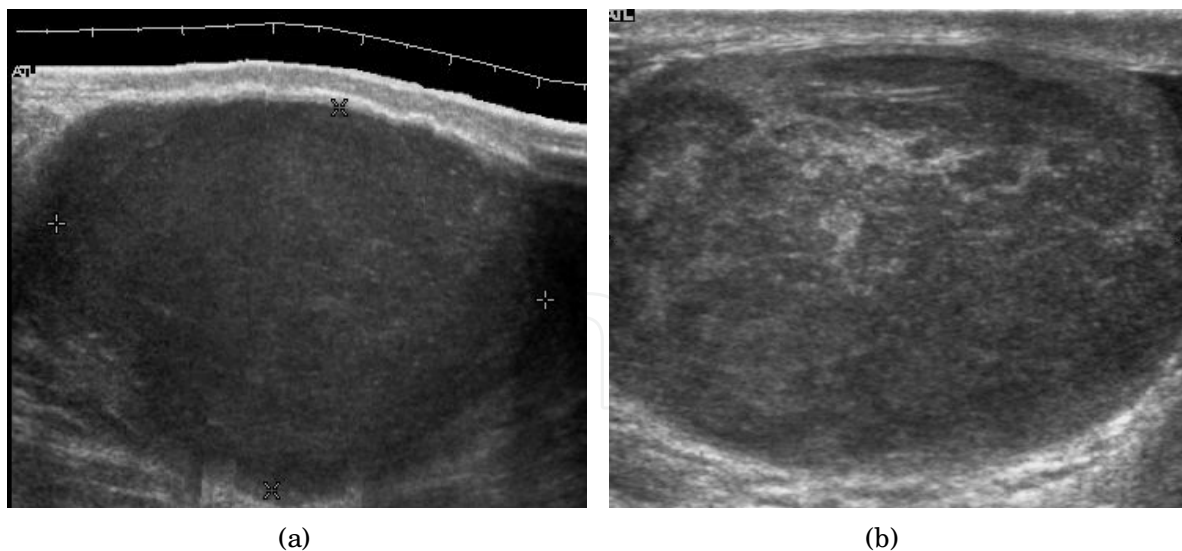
Seminoma. (a) Seminoma usually presents as a homogeneous hypoechoic nodule confined within the tunica albuginea. (b) Sonography shows a large heterogeneous mass is seen occupying nearly the whole testis but still confined within the tunica albuginea, it is rare for seminoma to invade to peritesticular structures
